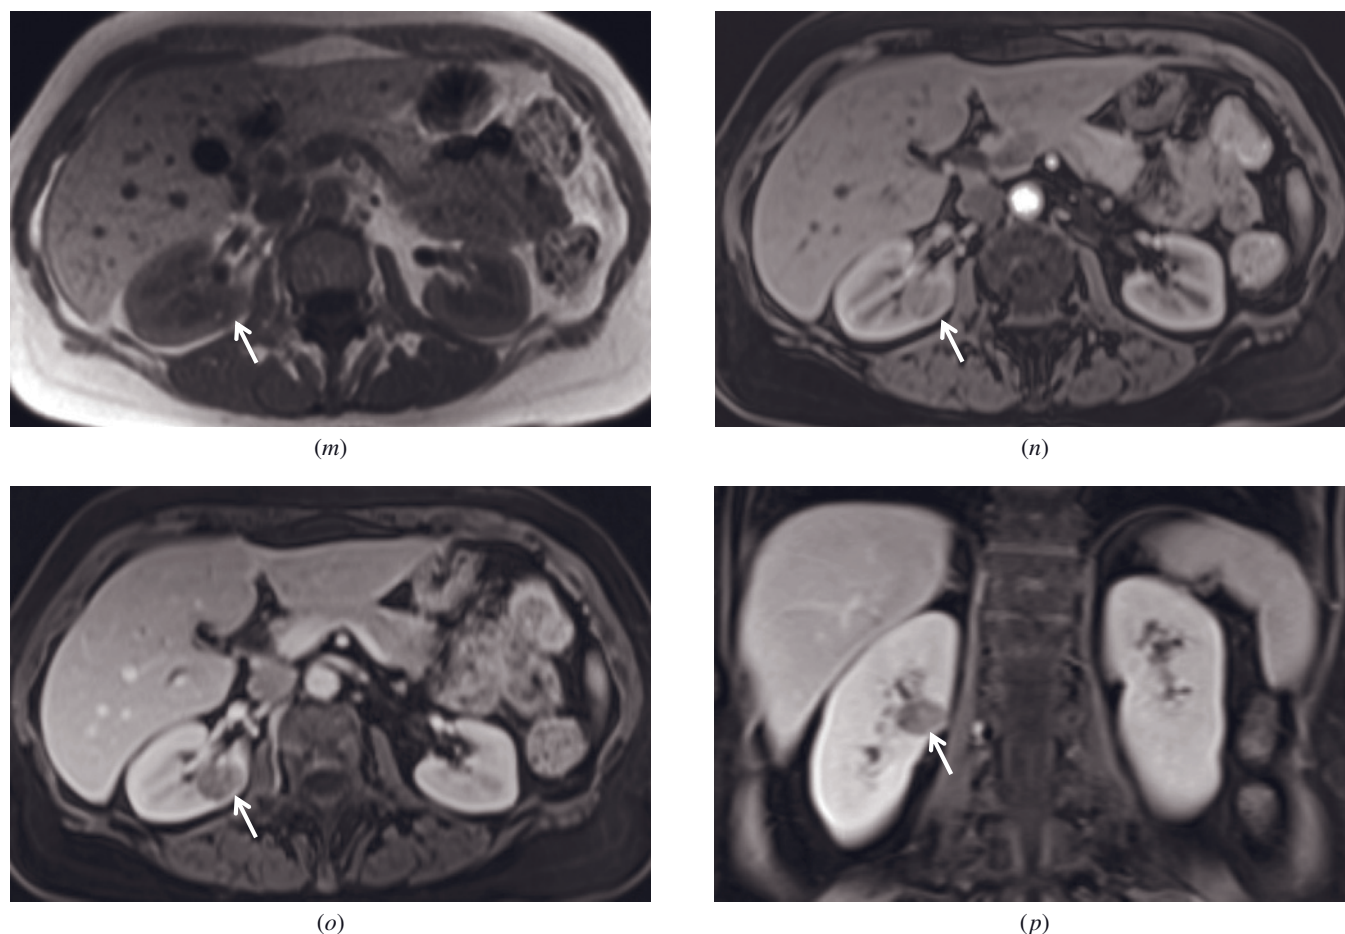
(Continued) arterial dominant (*n*) and hepatic venous phase (*o*) fat-suppressed 3D-GE, and coronal T1-weighted fat-suppressed interstitial-phase 3D-GE (*p*) images demonstrate renal cell cancer in the right kidney in another patient. The tumor has a hypovascular nature and shows mild progressive enhancement on postgadolinium images (*n-p*).
